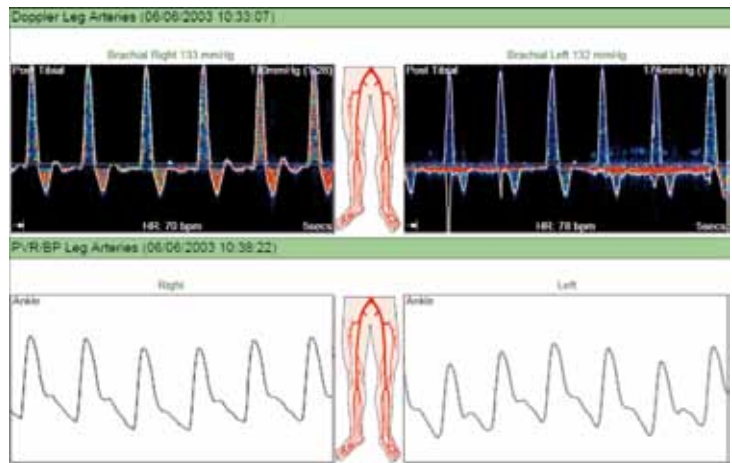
Right leg has normal flow, pressure and ABI with normal (grade A) PVR. Left leg has moderate PAD with monophasic Doppler waveform, low pressure and ABI, and poor, low amplitude PVR waveform (Grade D)
